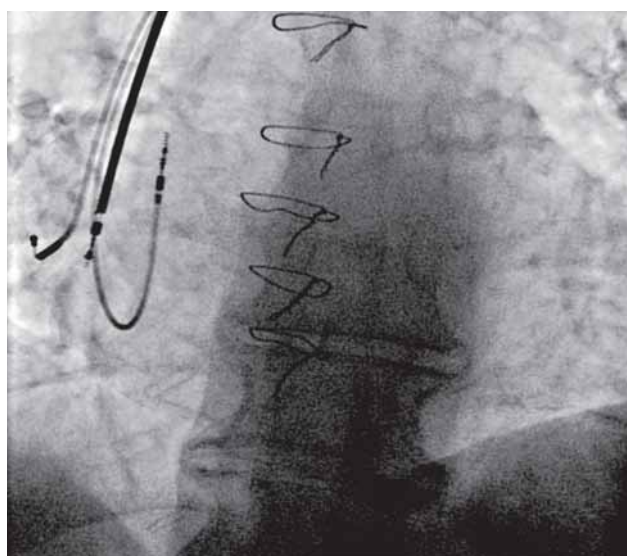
Displaced leads confirmed by x-ray
